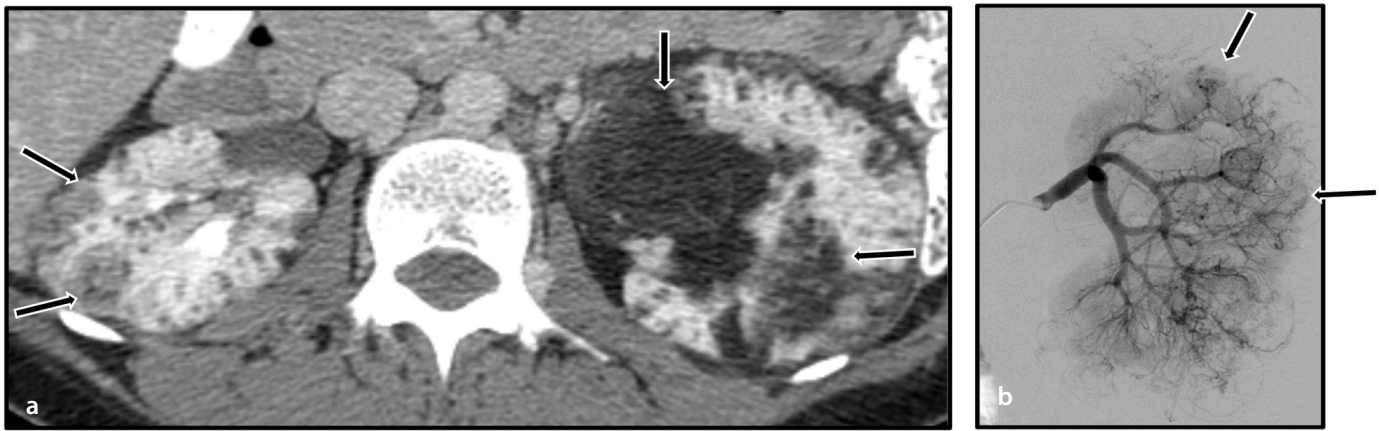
An axial contrast-enhanced CT scan (a) at the level of the kidneys demonstrates innumerable bilateral renal masses with intralesional macroscopic fat, diagnostic of angiomyolipomas (AMLs) (black arrows). Bilateral AMLs, the most common renal neoplasm associated with spontaneous hemorrhage, are seen in 95% of patients with tuberous sclerosis complex. They have the propensity to form pseudoaneurysms and present a higher risk of bleeding if they reach a size of >4 cm. (b) Digital subtraction angiography of the left kidney demonstrates opacification of the renal arteries with multiple tortuous tumor vessels and pseudoaneurysms (black arrows). This pattern is typical of multiple AMLs in the setting of tuberous sclerosis. CT, computed tomography.
